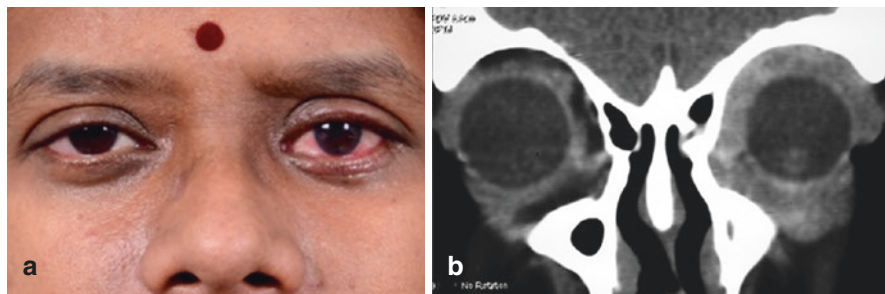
Orbital metastatic tumors. (a) A 56-year-old female with a history of breast carcinoma post treatment presenting with left inferior orbital mass. (b) Coronal CT orbit shows a diffuse mass in the left orbit and the biopsy proved to be metastatic carcinoma from breast
